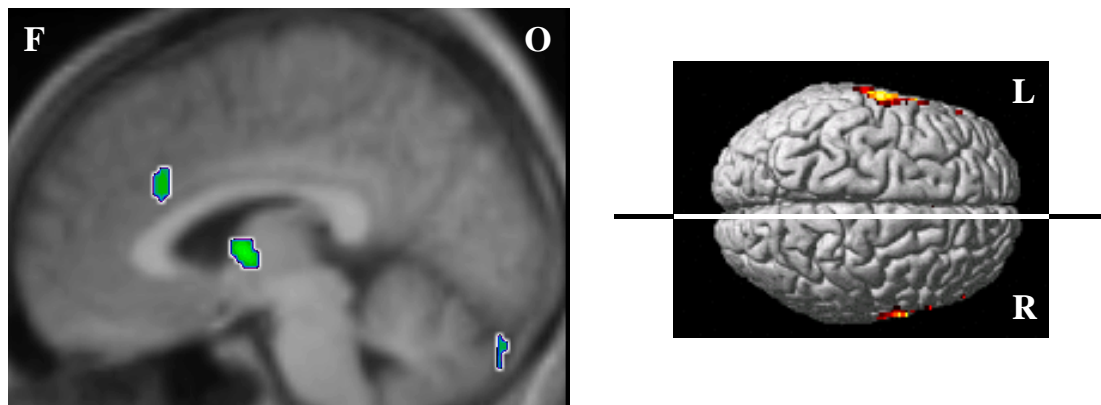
Right sagittal section (mean MRI image; section 6 mm from median as demonstrated in the right image) through clusters with increased activation in right anterior cingulate gyrus (BA 24) and right thalamus, showing the mean activation pattern during maximal distention relative to baseline (subtraction analysis: maximal distention condition – baseline condition). Analysis was run at the $p_{\text{uncorrected}} < 0.001$ level. Only the activation of the anterior cingulate gyrus was significant at the $p_{\text{corrected}} < 0.05$ level. (F = frontal, O = occipital, L = left, R = right)
